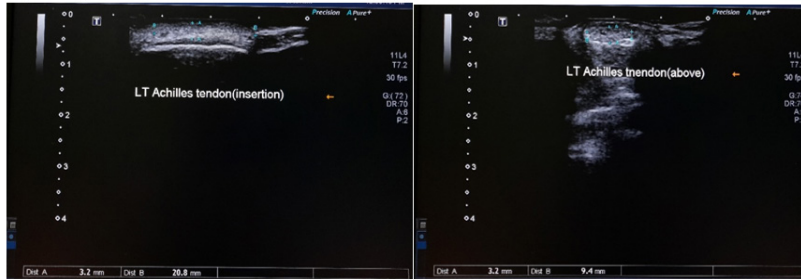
Linear MSK ultrasound of a 26-year-old female patient. The left AT measurements (thickness at the AT insertion into the calcaneus and above insertion: 3.2 mm and 3.2 mm, respectively; the width at the AT insertion into the calcaneus and above insertion: 20.8 mm and 9.4 mm, respectively).
